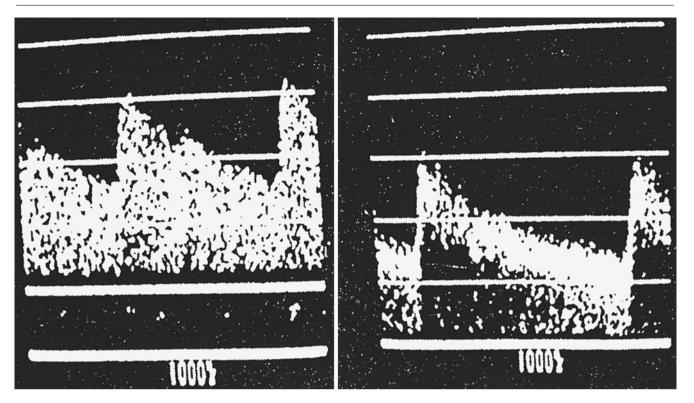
Left*: continuous-wave Doppler signal. Note the absence of a frequency window. *Right*: in contrast the pulsed wave Doppler signal has a frequency window
